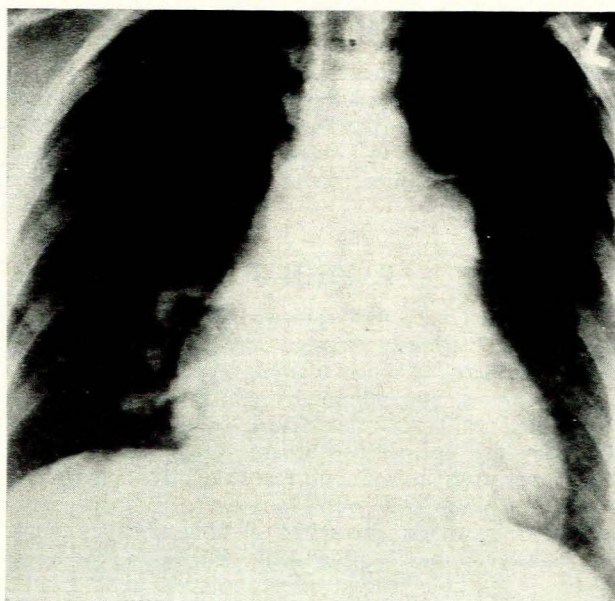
Chest radiograph showing the 'serpiginous' structure, viz. the PAVF, in the right lower lobe. A dilated main pulmonary artery is also visualized.
